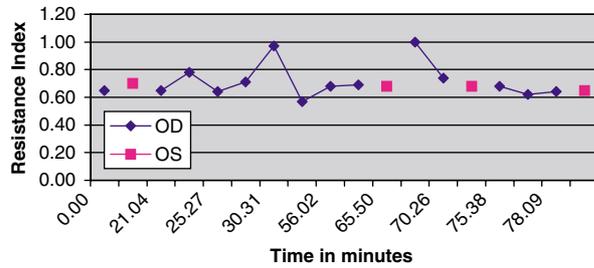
Colour Doppler of central retinal artery showed higher resistance index in right eye whenever in abduction, that is, 30.31 and 70.26 min. (Resistance index is peak systolic volume minus end diastolic volume divided by peak systolic volume).
